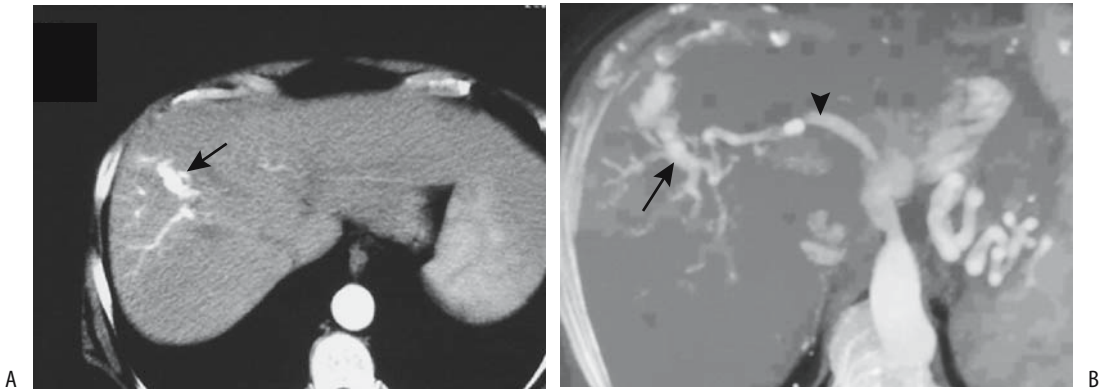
Postbiopsy arterioportal fistula. A: Computed tomography (CT) during hepatic artery phase reveals contrast in aorta and right anterior portal vein (arrow). B: Maximum intensity projection also during hepatic artery phase shows hepatic artery (arrow-head) and right portal vein branches (arrow). (Source: Gallego C, Velasco M, Marcuello P, Tejedor D, De Campo L, Frieria A. Congenital and acquired anomalies of the portal venous system. *RadioGraphics* 2002;22:141–159, with permission from the Radiological Society of North America.)
